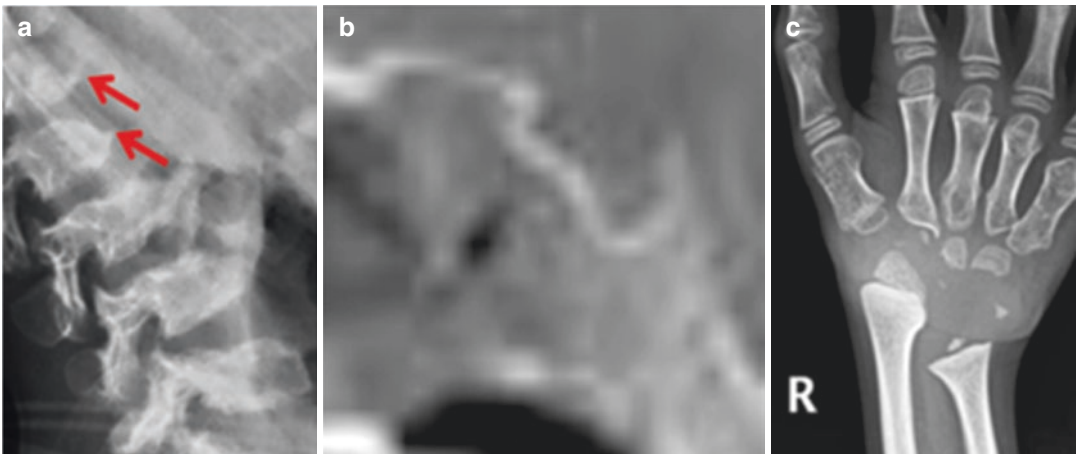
Hurler syndrome. (a) Lateral thoracolumbar spine radiograph shows platyspondyly with anteroinferior beaking (arrows). (b) Sagittal-reconstructed CT image of the sella (bone window) shows a “J”-shaped sella. (c)
